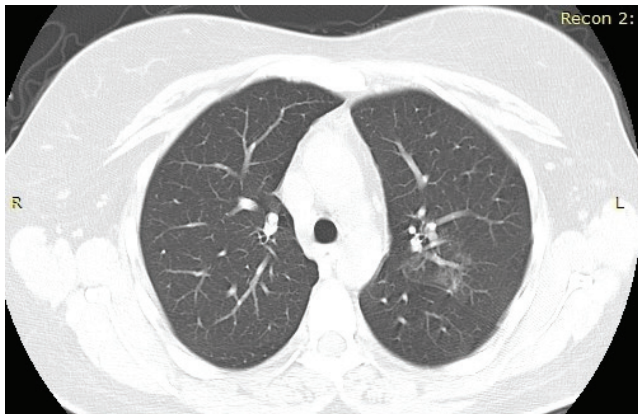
Chest CT scan after plasma exchange.
